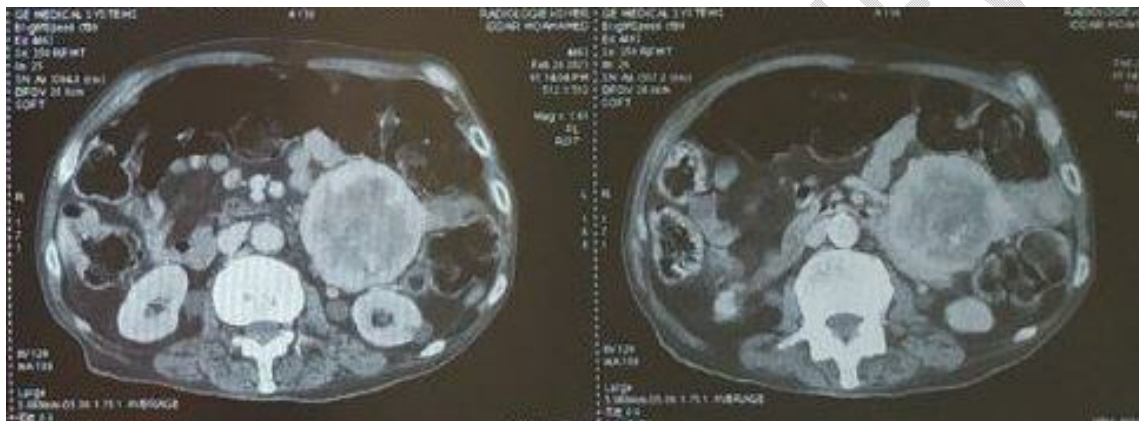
CT image of the stromal mass
